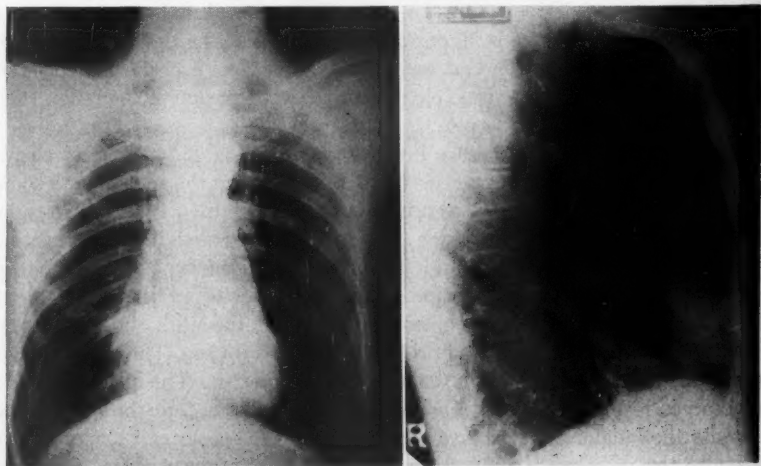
Case 1. Roentgenograms which show changes suggestive of atelectasis of the right middle lobe.
